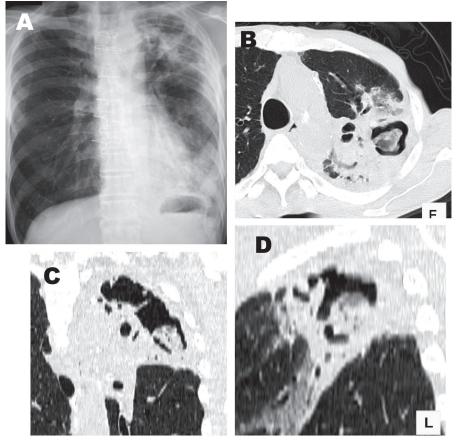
Chest radiograph (A) and axial (B), frontal (C) and lateral (D) images of multislice CT obtained on 7th hospital day. The cavity became larger and further progression of the infiltrates to the left lower lobe. The air crescent was observed in axial image. In frontal and lateral images infiltrates with airbronchograms were observed in the left upper lobe (S¹⁺² and S³).
